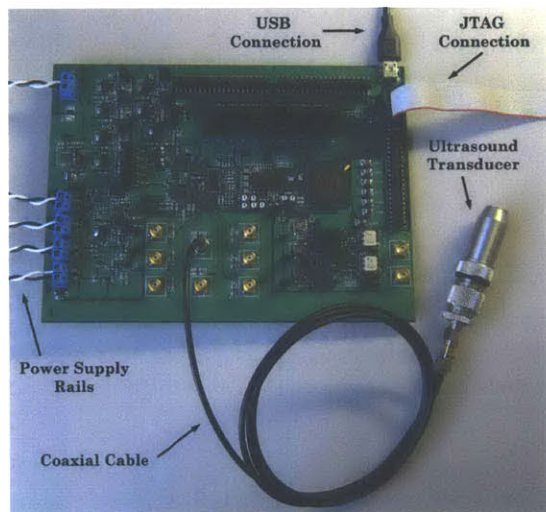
A picture of the operable Prototype I TCD ultrasound system.
